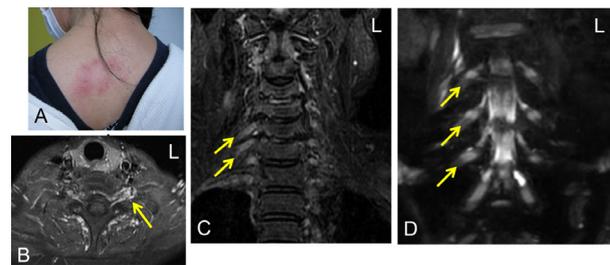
Herpes zoster (HZ) skin rash and MRI findings. (A) Patient 7 developed HZ in the left back of her trunk on the Th4 dermatome, and 5 days later she showed upper-limb paresis in the left C8 region. (B) Contrast MRI T1WI revealed high-intensity lesions with enhancements at the C8 nerve root region (arrow) (7). (C) Patient 10: Gd-enhanced cervical root coronary MRI T1WI showed high signals on both sides at the C6 and C7 nerve roots (right side arrows) (10). (D) Patient 12: Lumbar root coronary MRI using 3D NerveVIEW imaging showed high-intensity lesions on both sides at L2–4 spinal roots (arrows) (12). The HZ skin rash and CT/MRI images are reprinted with permission from references (7), (10), and (12).
